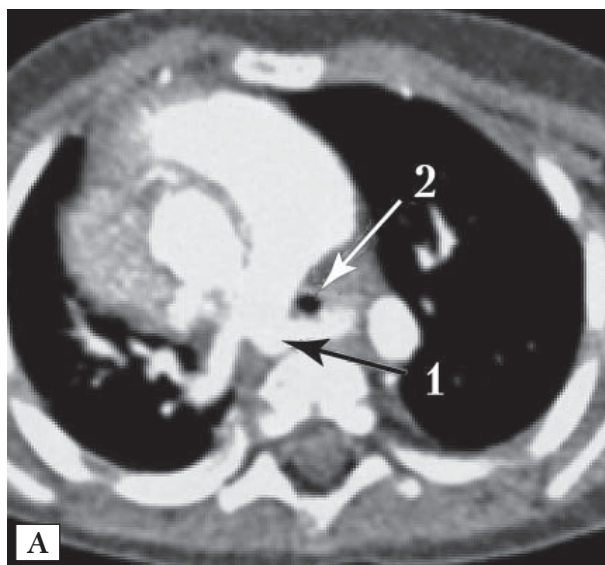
Chest CT with contrast enhancement in 8 months old patient with pulmonary artery sling associated with complete ring long segment tracheal stenosis. Axial scan (A). Pulmonary artery sling (1), congenital stenosis of the thoracic segment of the trachea (2). Chest CT, sagittal reconstruction (B). Long segment congenital stenosis of the thoracic trachea (length 4 cm (83%), the degree of narrowing 60%)
